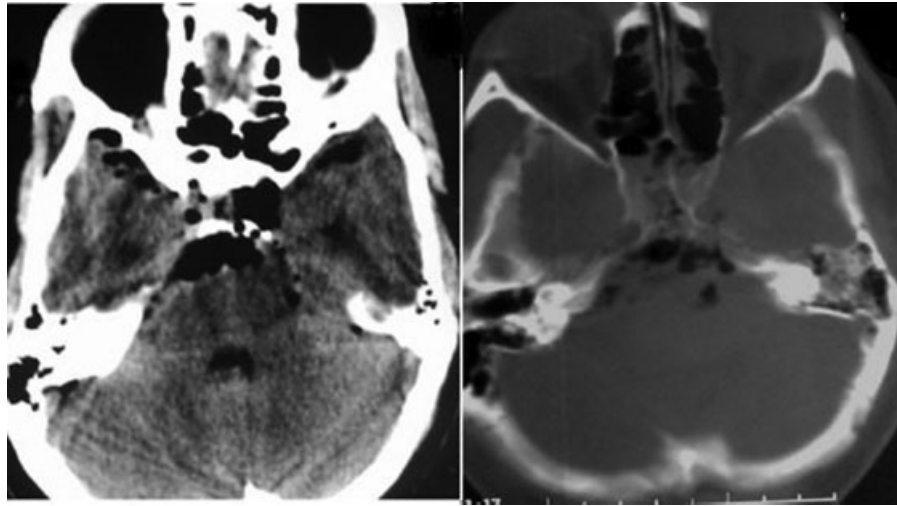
Computed tomography scan axial images shows skull base pneumocephalus with collection in sphenoid sinuses.
